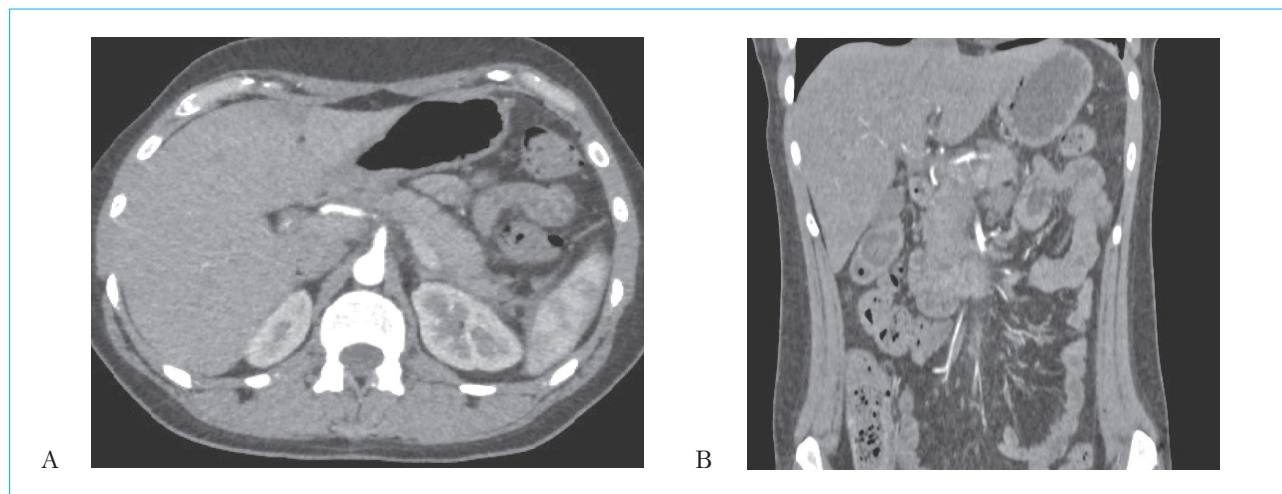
5А, В. CT scan of the abdominal organs a month after discharge from the hospital
